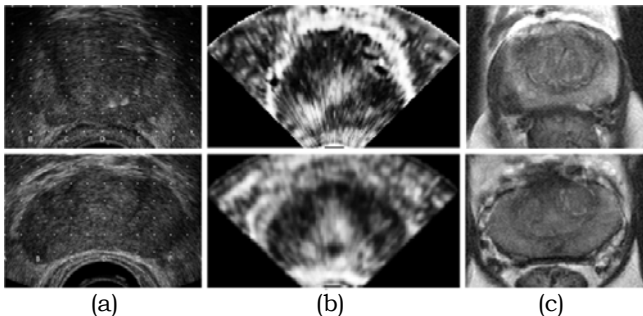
(a) Transverse Ultrasound B-Mode, (b) Ultrasound Elastography and (c) MRI images of the Prostate for two patients.
